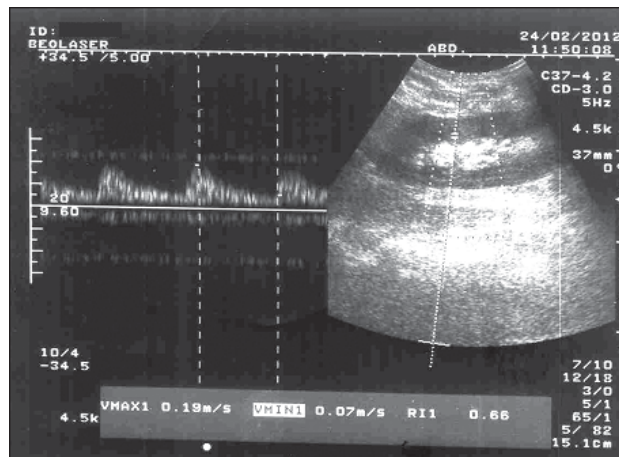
Graft Doppler ultrasonography after transplantation.
